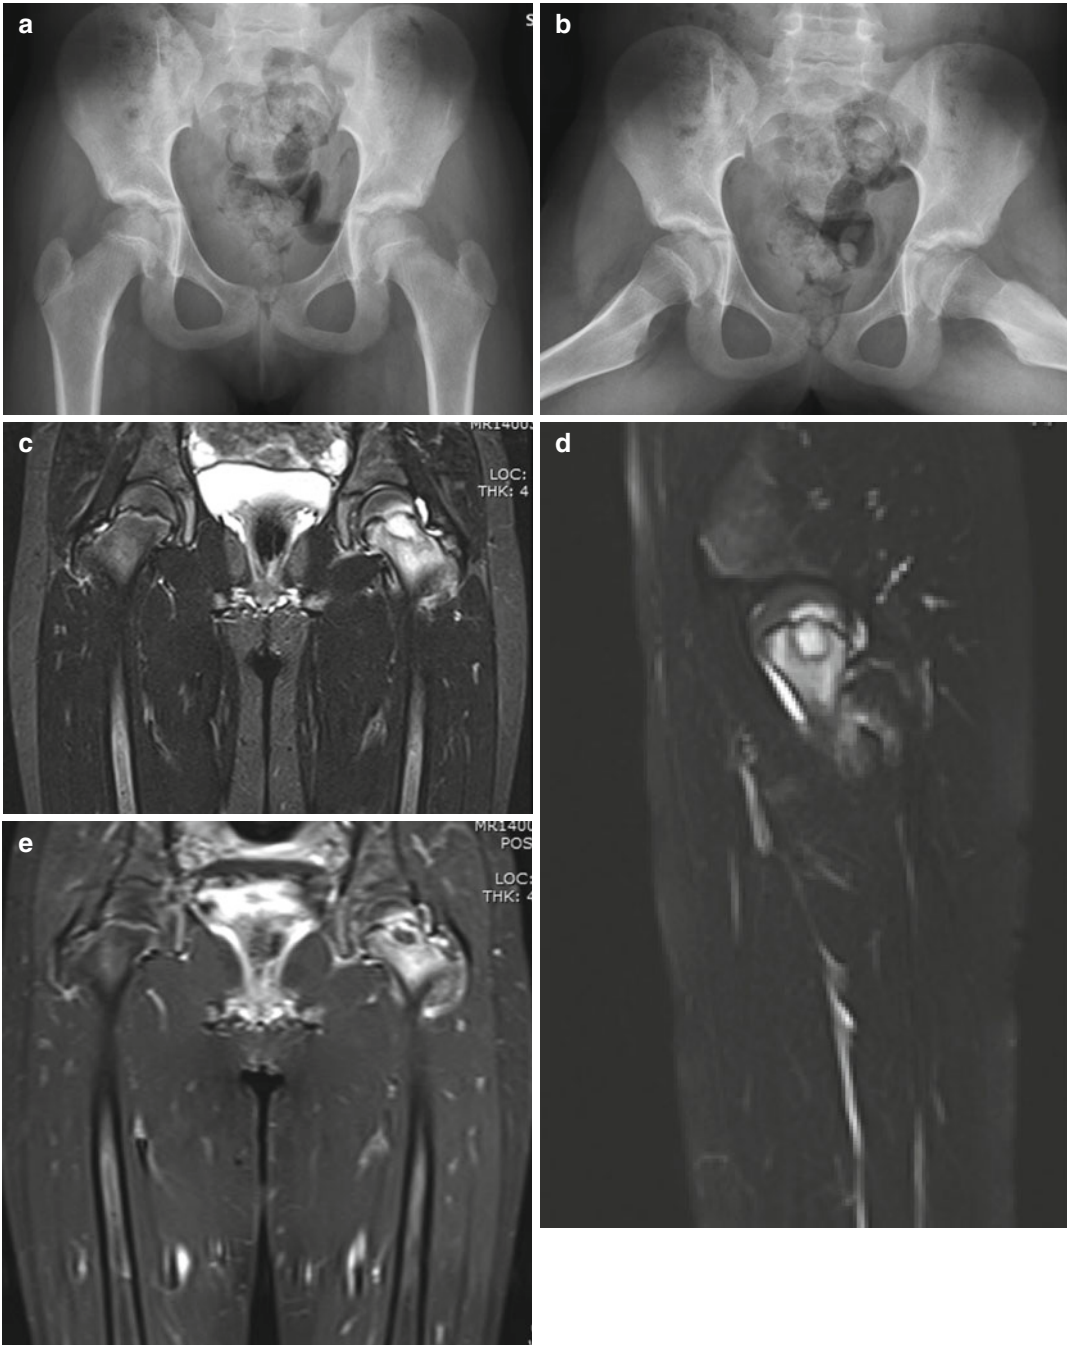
Proximal femoral subacute osteomyelitis in a 5-year-old girl. Plain AP (a) and frog lateral (b) radiographs of the pelvis demonstrate a very subtle lucency in the proximal (*left*) femoral metaphysis just distal to the physis. MRI demonstrates osteomyelitis. The coronal
